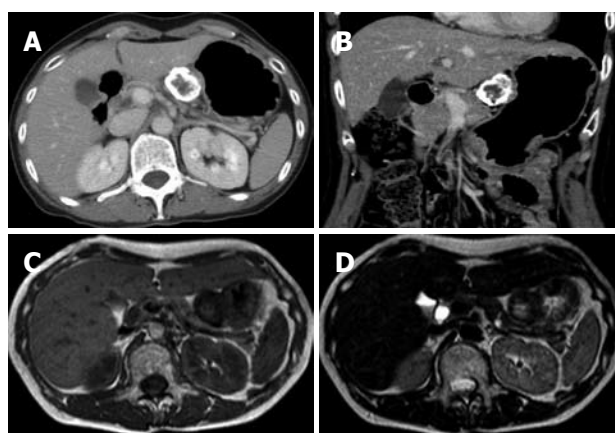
Computed tomography and magnetic resonance imaging findings. Contrast-enhanced axial (A) and coronal (B) computed tomography examination demonstrated that the marginal zone of the tumor was calcified, and that the internal portion of the tumor was enhanced heterogeneously. Magnetic resonance imaging T1-weighted image (C) and T2-weighted image (D) revealed a low intensity marginal zone of tumor reflecting calcification.
